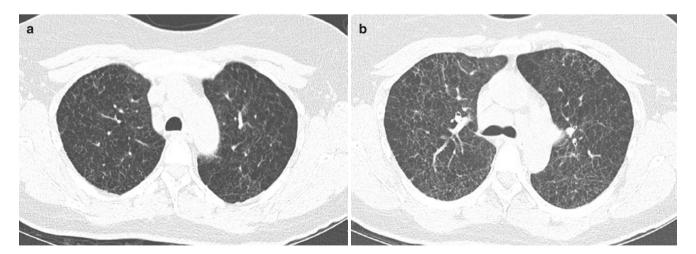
LCH in a middle-age smoker with resolving pneumonia in the right lower lobe. (a–d) Axial CT images show bizarre-shaped cysts sparing the lung bases. Wall thickening in the cysts in the right lower lobe is due to resolving pneumonia
